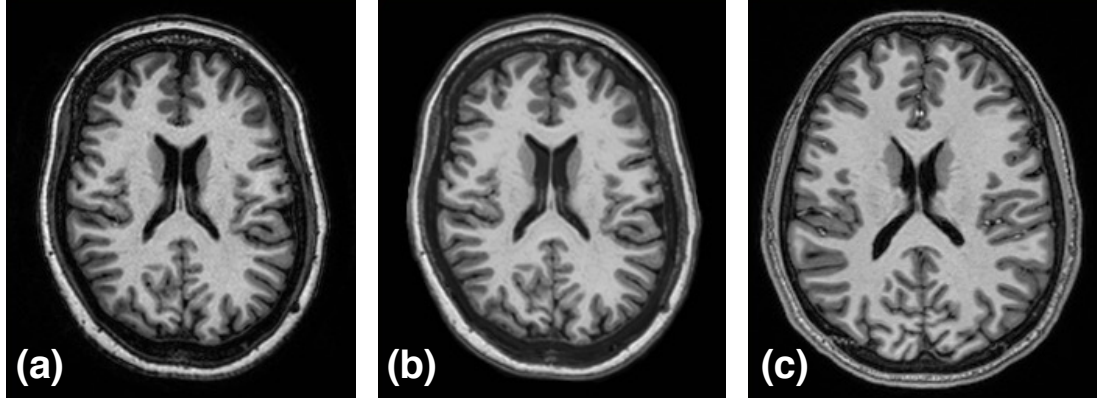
Visualization of the T1-w MR image harmonization. (a) An axial slice from a subject in the SCA data set before harmonization. (b) The same axial slice after harmonization. (c) Harmonization target in the MTBI data set.
